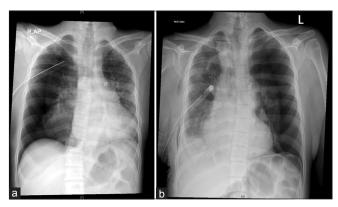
(a) Chest X-ray showed a large right-sided pneumothorax with chest tube. (b) Chest X-ray 1-day postoperative showed the large left-sided pneumothorax
